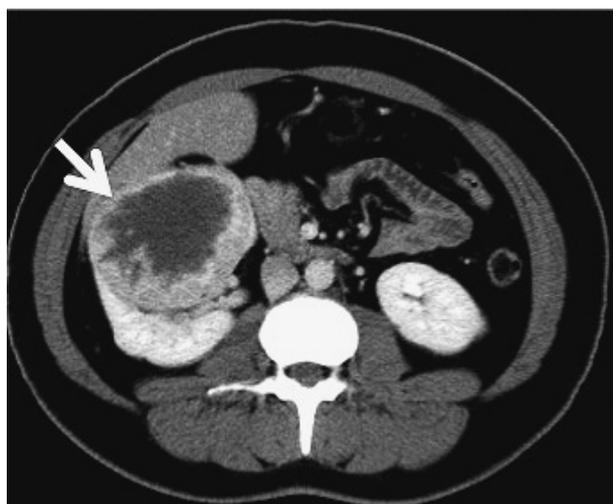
Preoperative abdominal computed tomography
